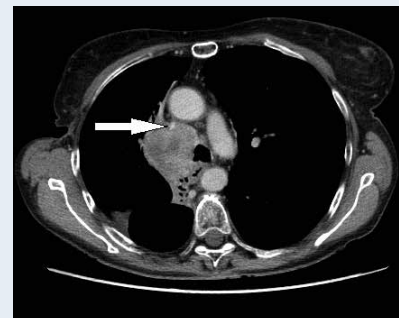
Computed tomography-angiography of the chest presented narrowed vena cava superior by surrounding tumour mass (arrow)
